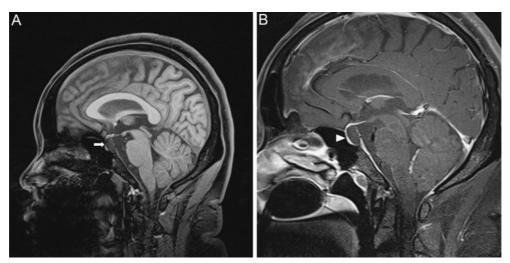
(A) A sagittal T1-weighted magnetic resonance (MR) image showing a 1.2×0.9×1.4 cm sized well-defined low signal intensity sellar lesion in the posterior aspect of the pituitary gland (white arrow). (B) A gadolinum-enhanced T1-weighted image showing no contrast in the cyst and a thin enhancing rim of surrounding compressed pituitary tissue (arrow head). Rathke's cleft cyst.
